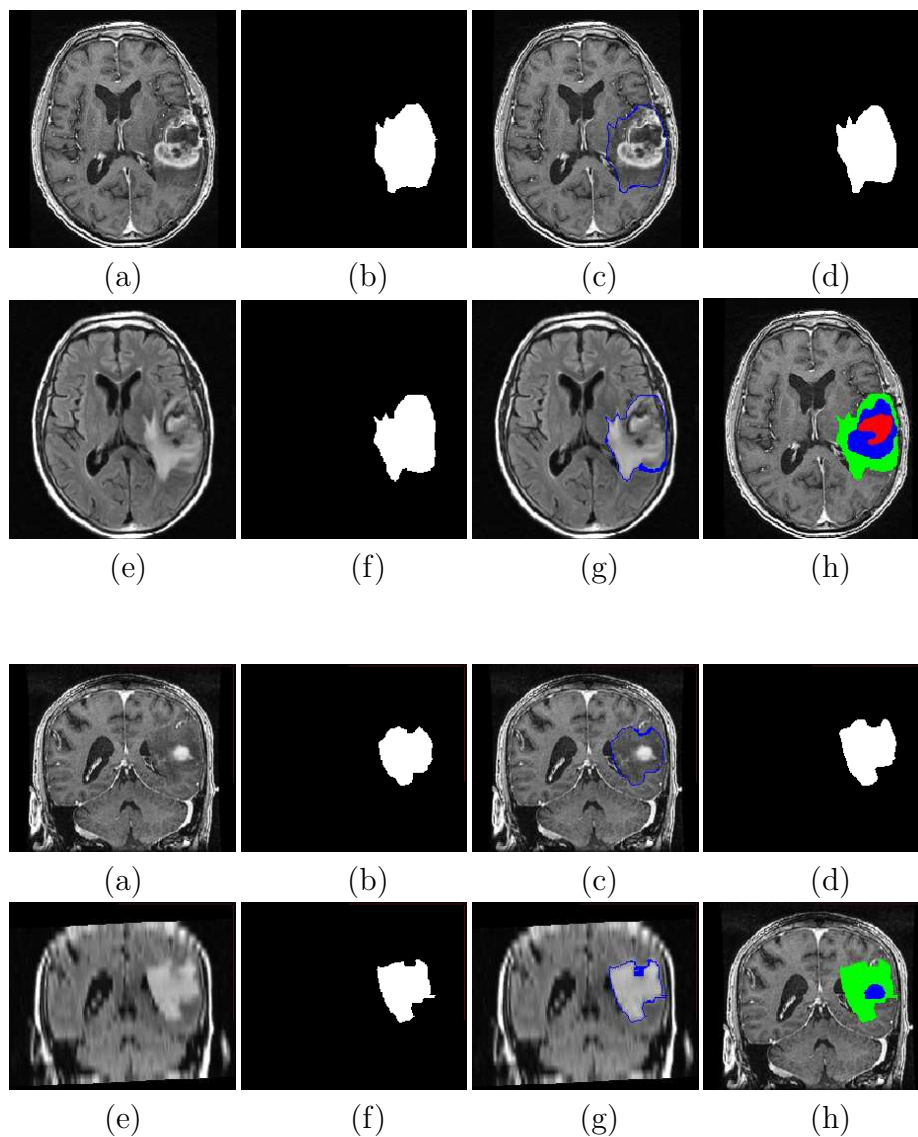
Segmentation of edema (an axial and a coronal slice). (a) Original CE-T1w image. (b) Segmented edema on the CE-T1w image. (c) Result superimposed on the original image. (d) Manually segmented edema. (e) Original FLAIR image. (f) Segmented edema on the FLAIR image. (g) Result superimposed on the original image. (h) Result of the tumor, edema and necrosis segmentation superimposed on the original image. Red, blue and green area represent necrosis, tumor and edema respectively.
